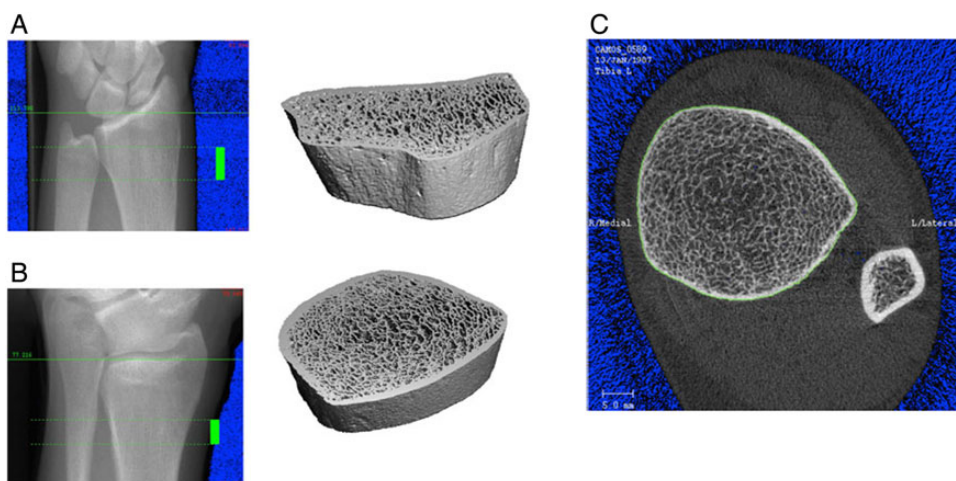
A typical setup of HR-pQCT for patient measurements. (A and B) The procedure for HR-pQCT analysis requires a 'scout view' x-ray of the radius (above) or tibia (below) so that the operator can select the region of interest for scanning (solid bar). Subsequently, three dimensional data can be obtained in the scan region (right). (C) A typical section from HR-pQCT showing the ultradistal tibia and fibula. Adapted from [4].
